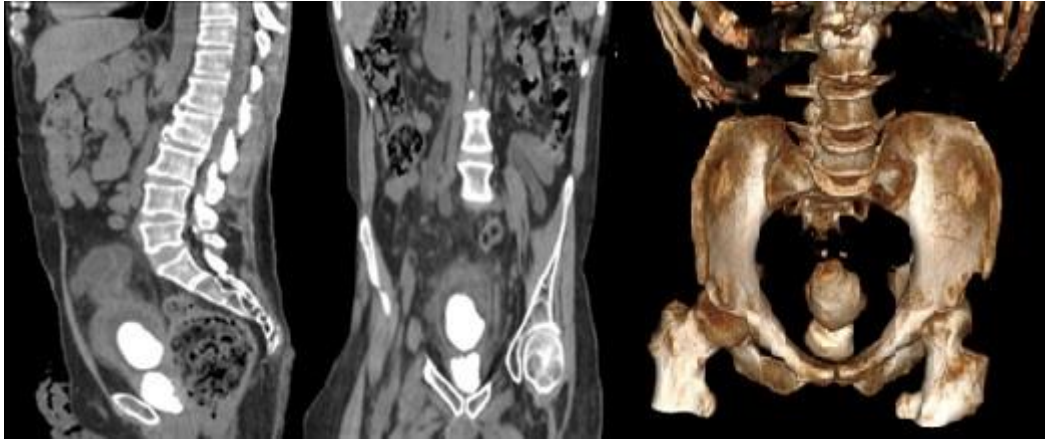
A CT scan showing two bladder stones.
